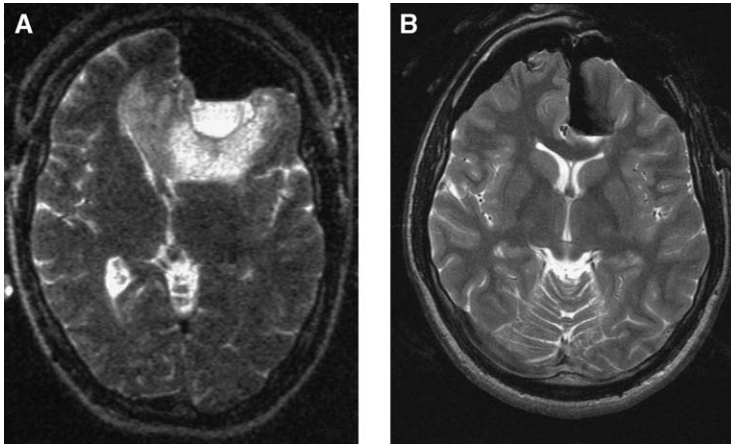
Comparison of intraoperative image quality in similar clinical cases of left frontal low-grade gliomas examined with T2-weighted imaging. (A) Low-field MRI with a 0.2-T Magnetom Open scanner (Siemens Medical Solutions, Erlangen, Germany). (B) High-field MRI with a 1.5-T Magnetom Sonata scanner.
